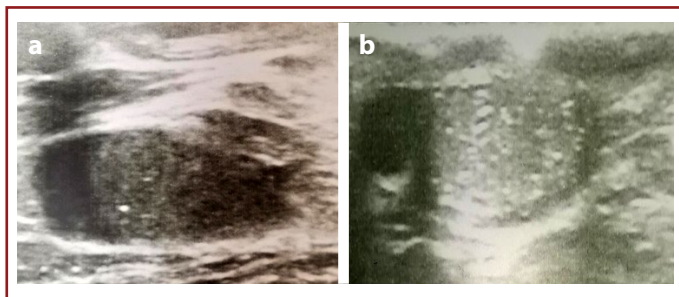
(a) Ultrasonographic image of focal testicular microlithiasis (A 5-year-old boy with unilateral undescended testis; Patient #12). (b) Ultrasonographic image of diffuse testicular microlithiasis (A 7-year-old boy who presented with testicular pain; Patient #9).
